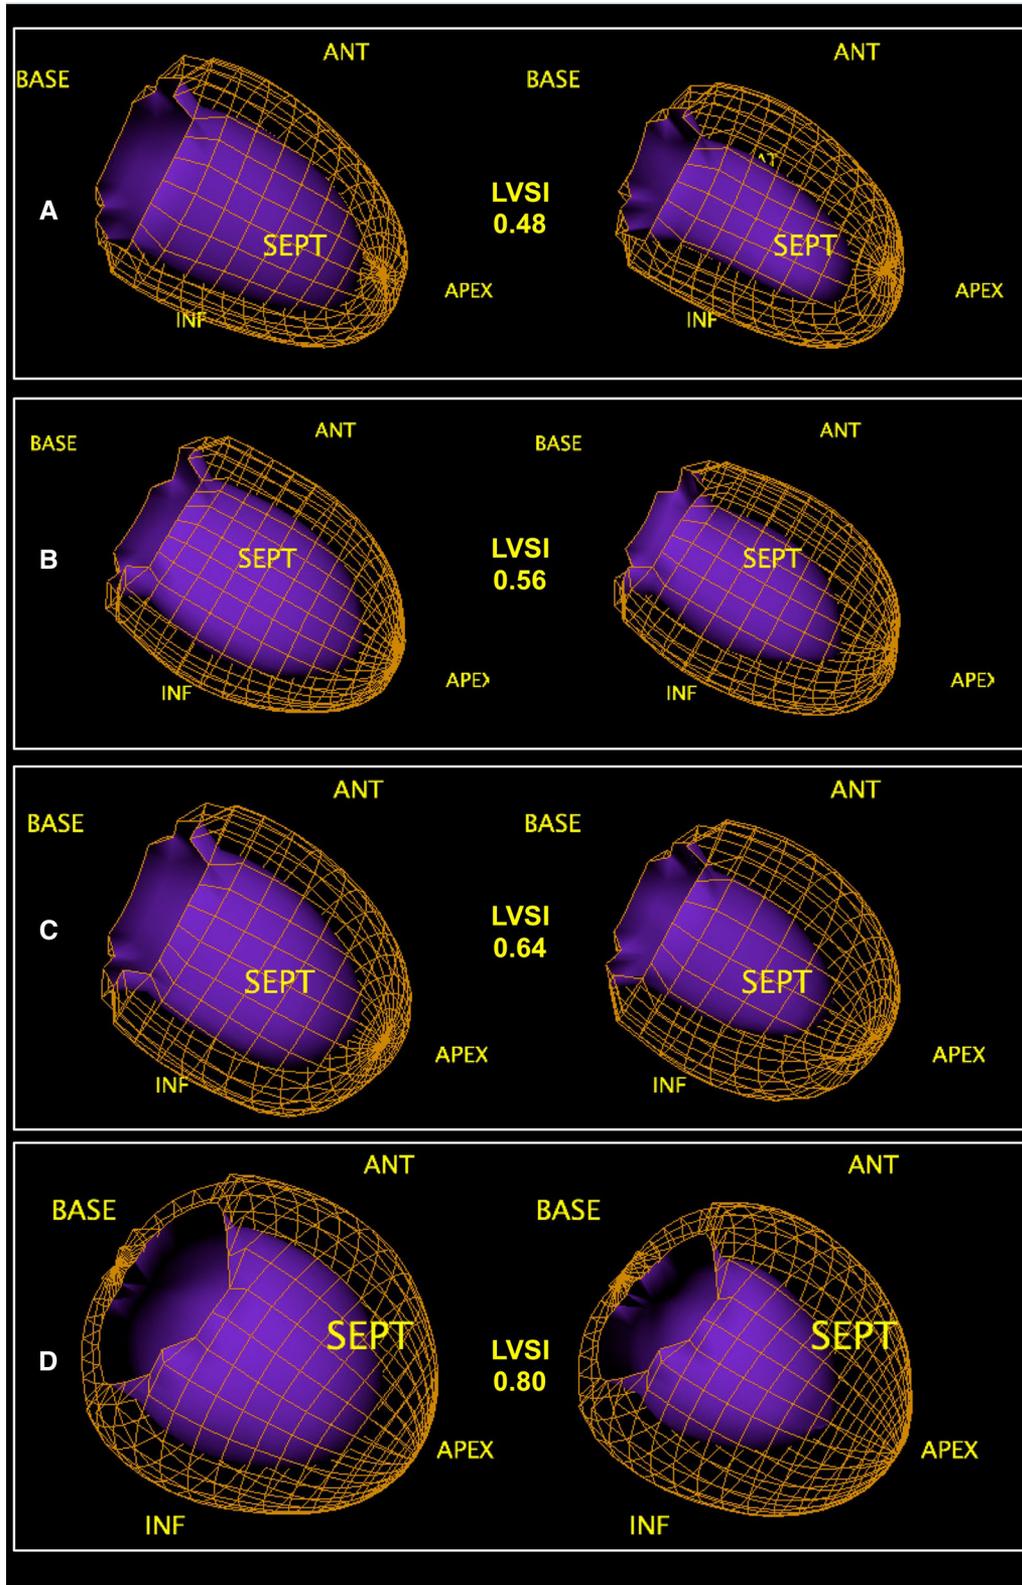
End-diastolic and end-systolic gated SPECT images in patients with normal (A), mildly increased (B), moderately increased (C), and severely increased (D) LVSI.
